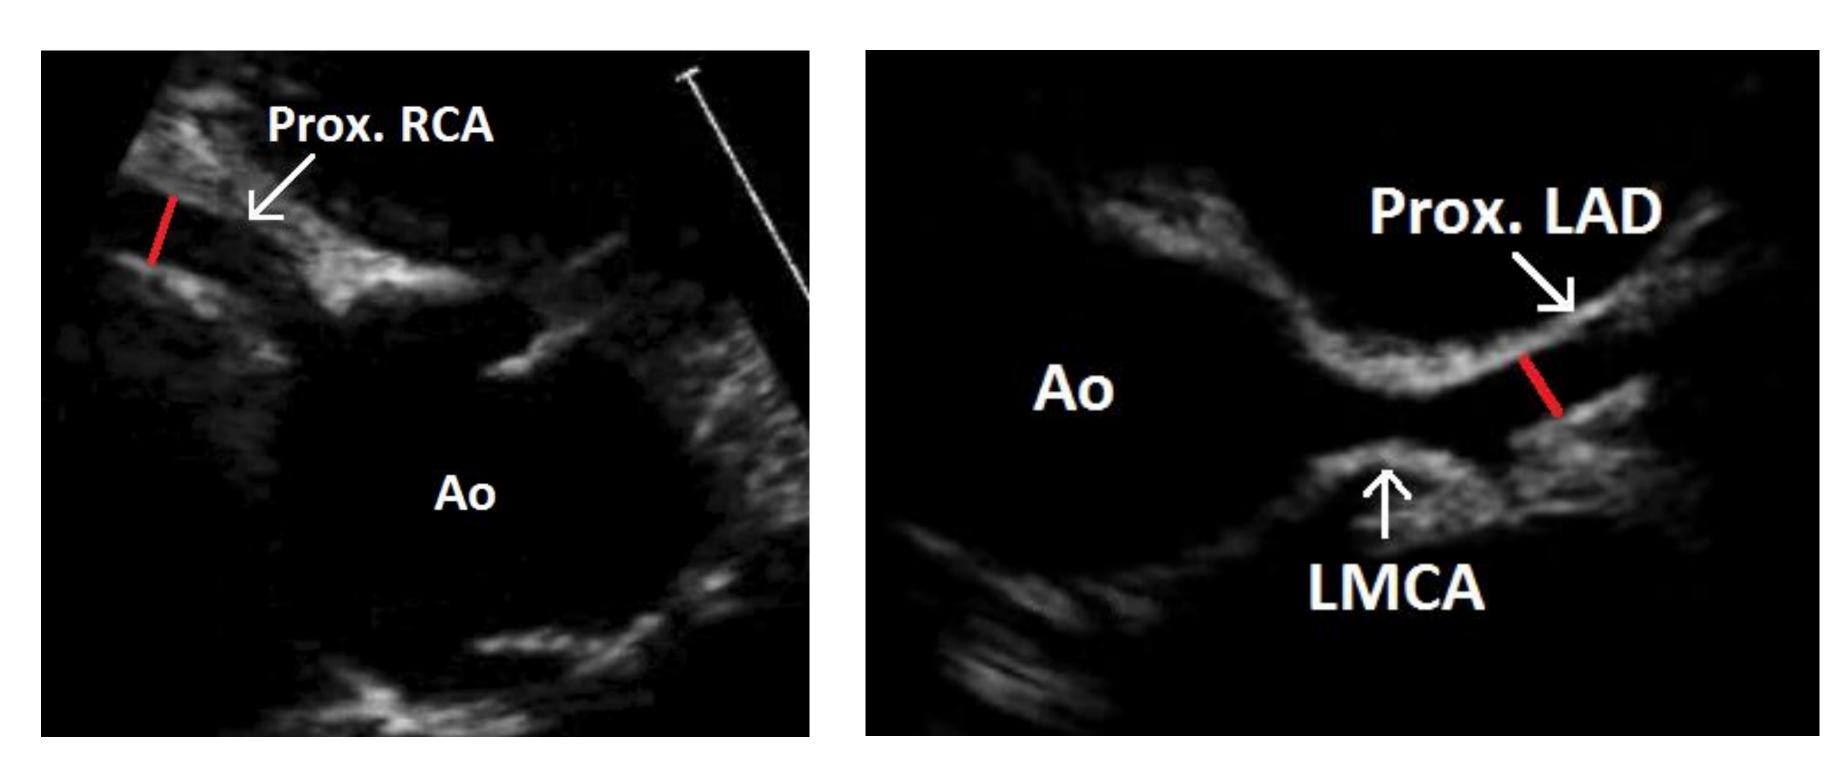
Example coronary artery intraluminal measurements of the proximal right coronary artery (RCA) and proximal left anterior descending (LAD) coronary artery obtained by echocardiography
